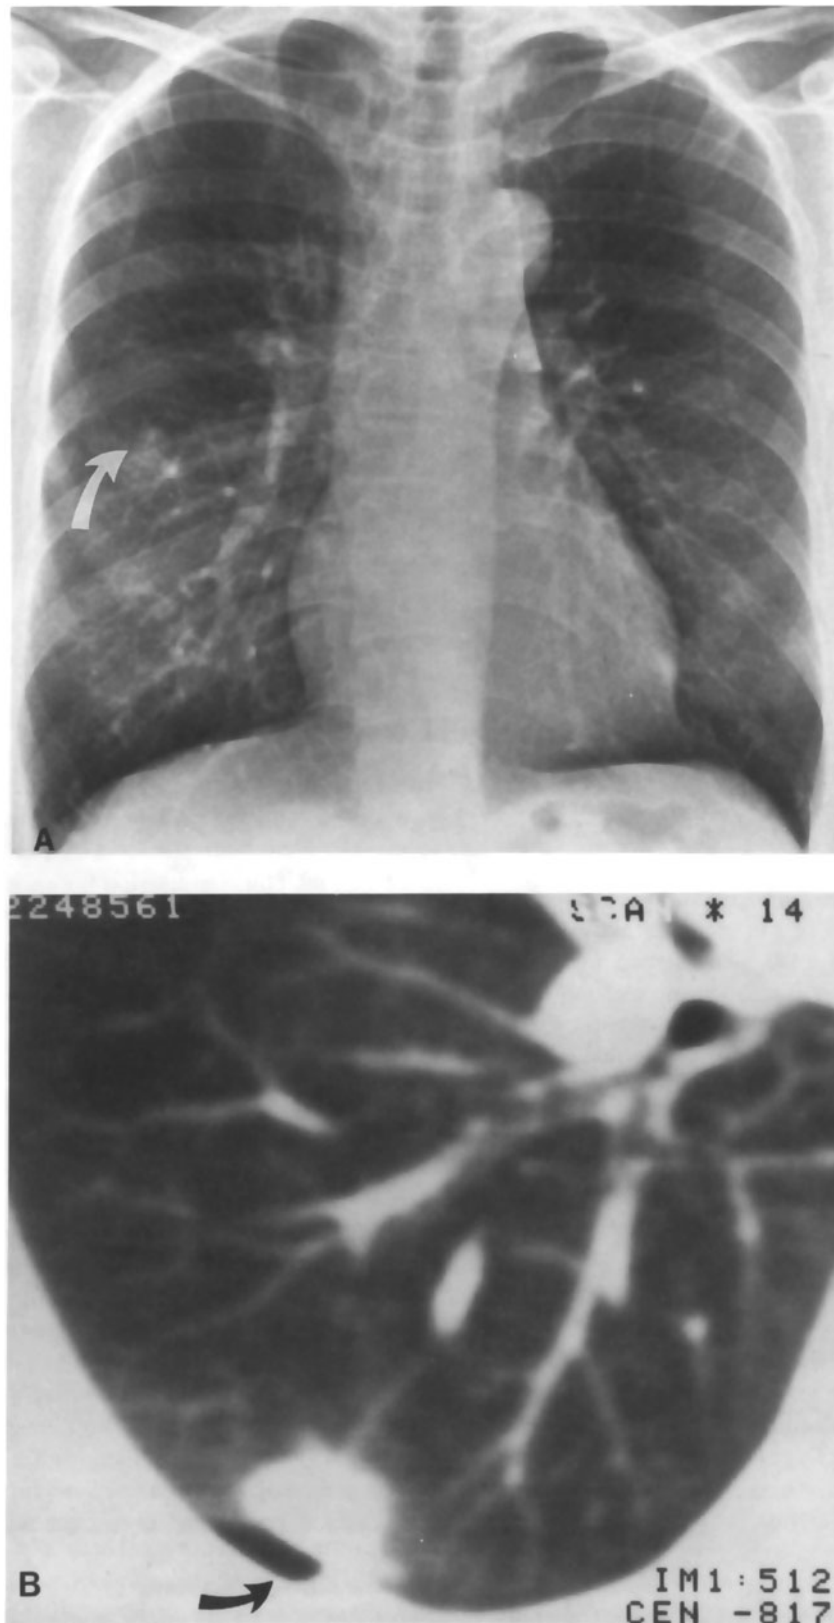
Asymptomatic pulmonary cryptococcosis. (A) A subtle, small, nodular opacity is suggested in the right mid-lung zone of a renal transplant patient. (B) A CT scan confirms a solitary peripheral nodular opacity, subsequently proven by transthoracic needle aspiration biopsy to be due to *C. neoformans* infection.
